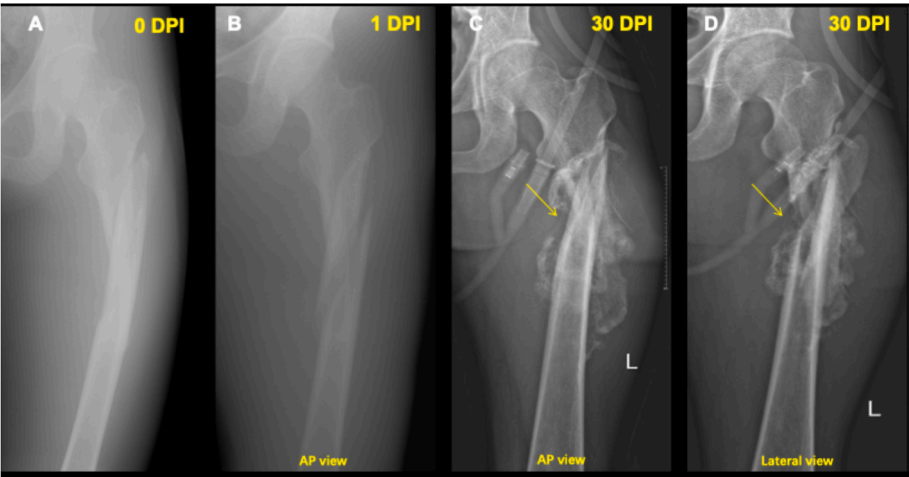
Case demonstrating robust callus formation and malalignment. Optimal alignment was achieved after manual reduction at 1 DPI (A, B). Preoperative radiographs show extensive bony callus formation with malalignment due to displacement of the fracture parts (C, D).
